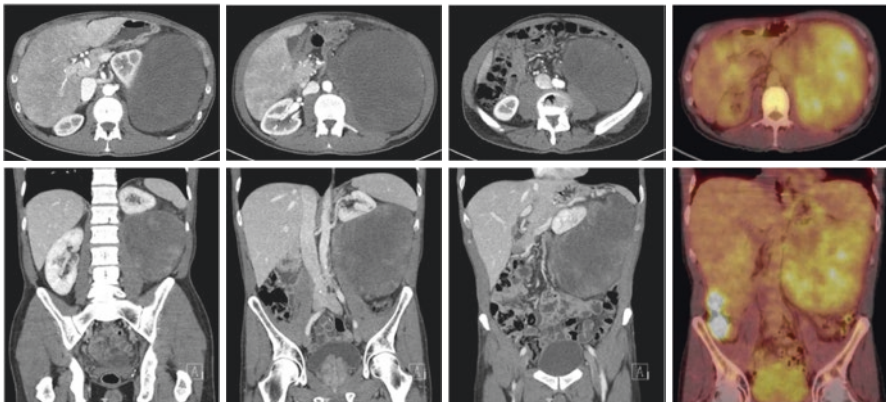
CT scan shows a certain heterogeneity inside the lesion. In PET-CT, we observed intratumor variations in glycolytic metabolism, with variations in SUV values. This finding can guide the most appropriate place to perform image-guided biopsy. The definitive pathologic diagnosis was an inflammatory liposarcoma with de-differentiated areas
